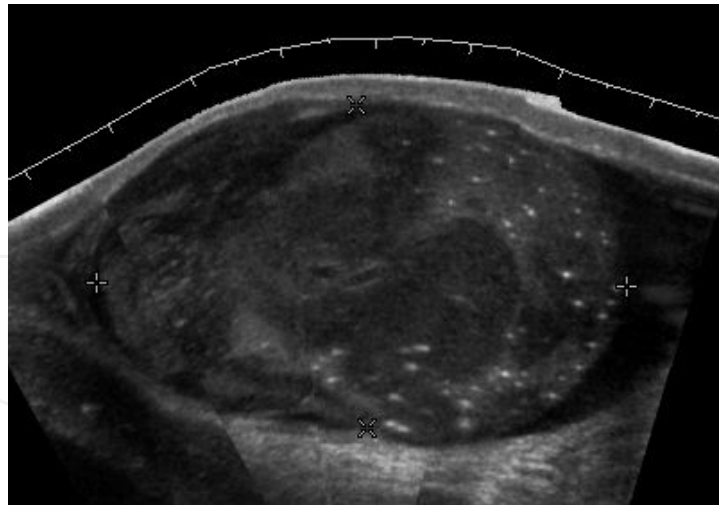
Primary Lymphoma. Longitudinal sonography of a 64 year-old man shows a lymphoma mimicking a germ cell tumor
